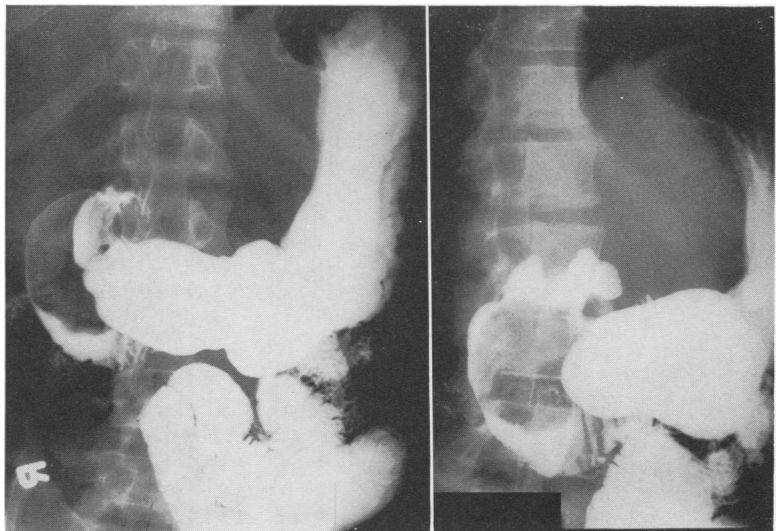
Preoperative gastrointestinal x-ray shows large duodenal mass in patient with Brunner's gland adenoma (Case 2).
